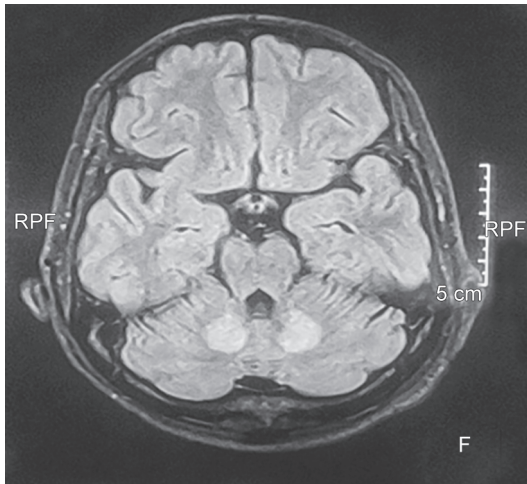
T2/FLAIR hyperintensities in the bilateral dentate nucleus
